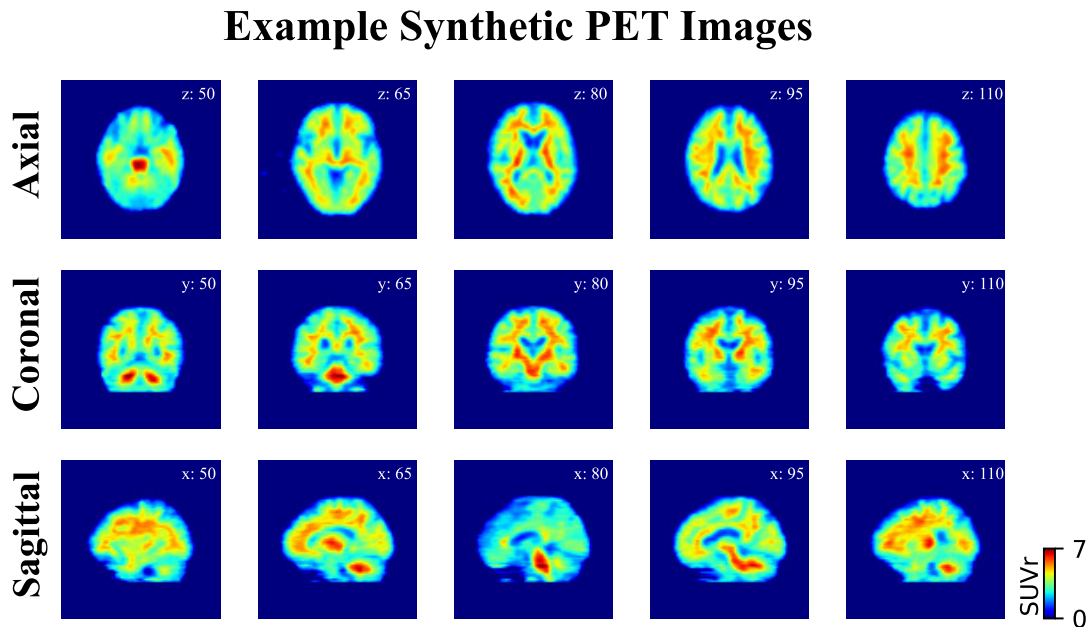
Representative example of synthetic amyloid-beta PET images. Five slices in each orientation are shown with the numbers that correspond to the slice in the MNI atlas. The subject is age 64 with a Clinical Dementia Rating (CDR) score of 2. Here the 2D images are all independently estimated and then reassembled into a 3D volume. In general, there is a high degree of continuity in the SUVR between slices, although there are some minor discrepancies towards the base of the brain.
